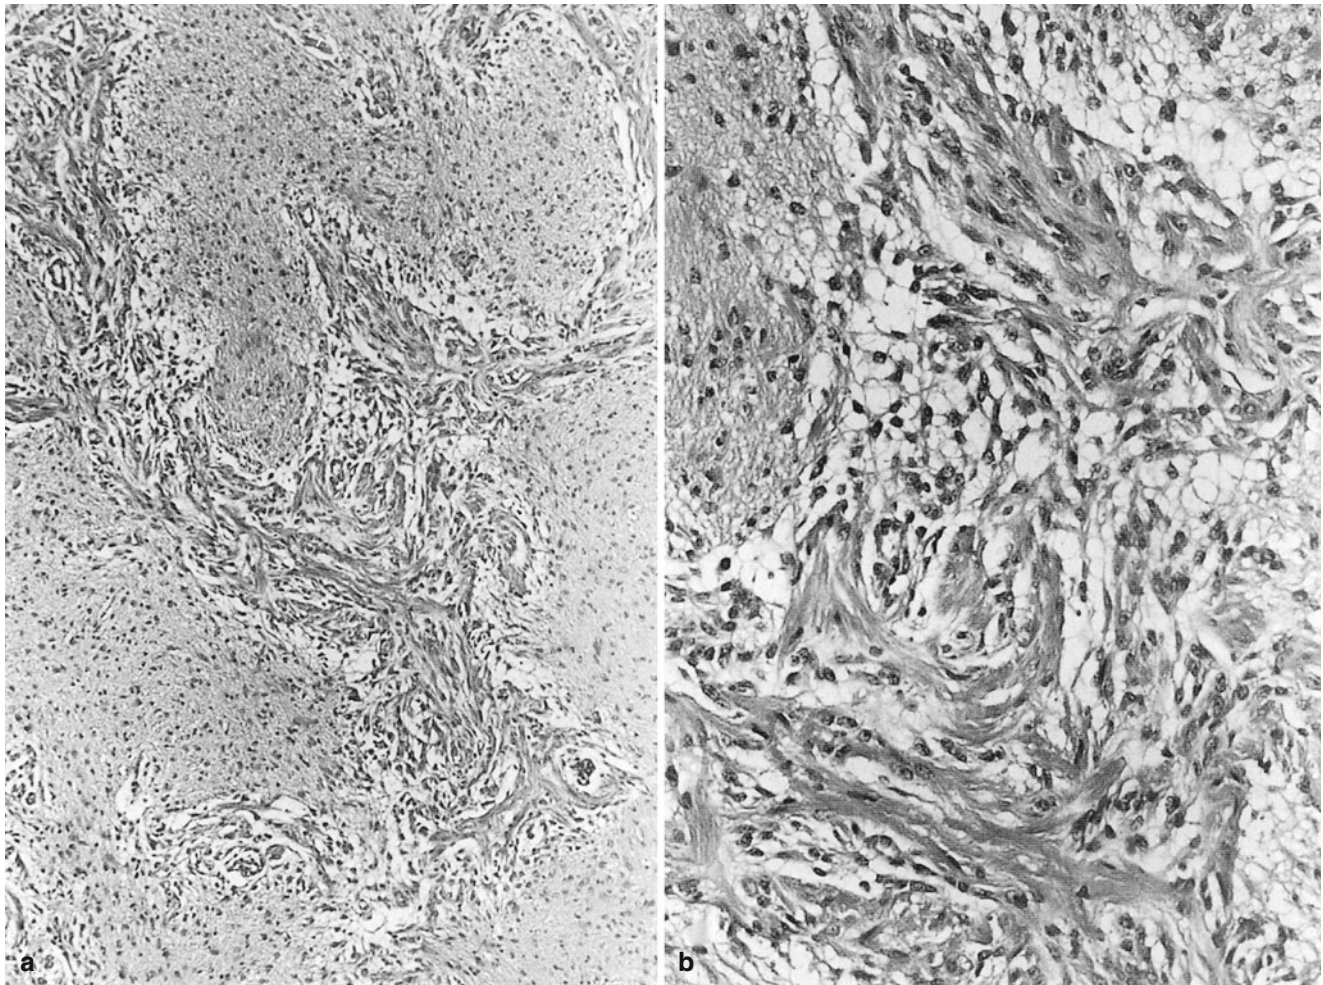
Optic glioma. Seven-month-old male with seizures, facial twitching, and right-eye deviation. CT scan revealed obstructive hydrocephalus and a 3×4-cm suprasellar, solid, and cystic mass arising from the optic chiasm, compressing the third ventricle and producing enlargement of right optic foramen. (a) The cerebral cortex is infiltrated by a
